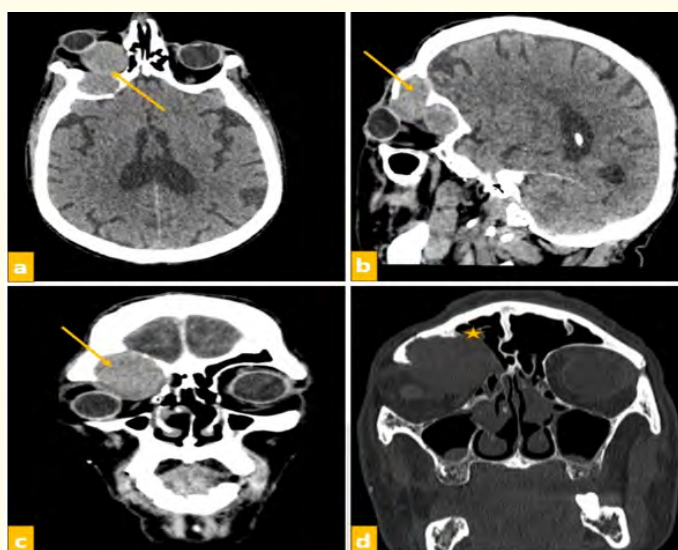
CT scan in parenchymal window (axial [a], sagittal [b], coronal [c]) and bone window (d) showing a right frontal mucocoele (arrow) causing bone lysis of the frontal sinus wall (star) with intra-orbital extension.
